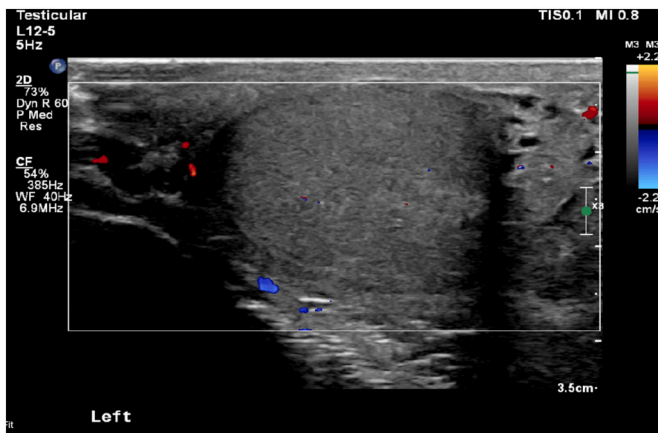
Left testis ultrasound on presentation to the Emergency Department.
